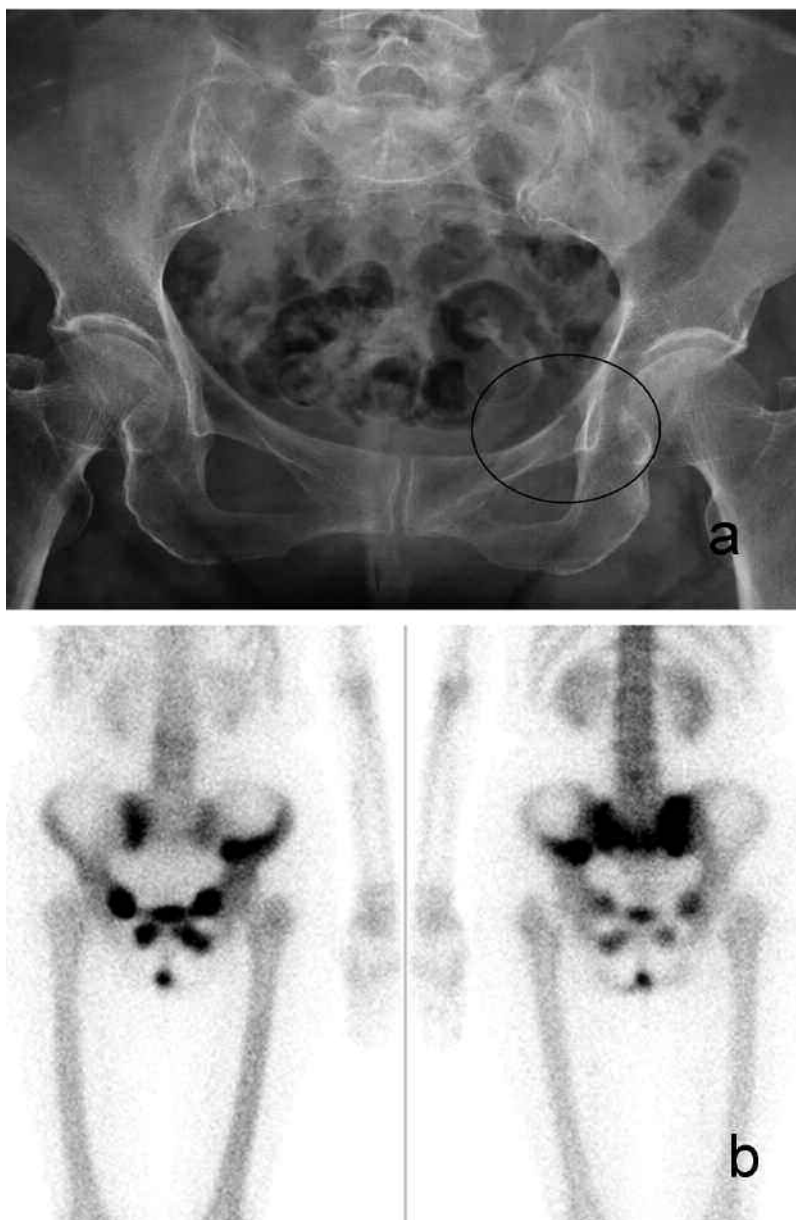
A. Plain radiograph reveals left superior ramus fracture (circle). No fracture noted on other 3 rami. B. Bone scan demonstrates increased uptake of 4 rami and sacrum ("H" sign), consistent with insufficiency fractures.
